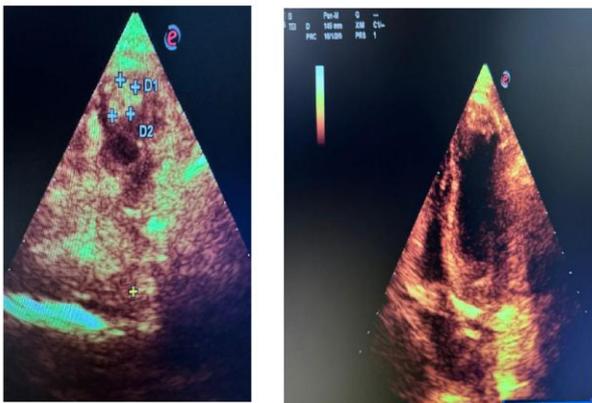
2D echocardiography and colour doppler.
